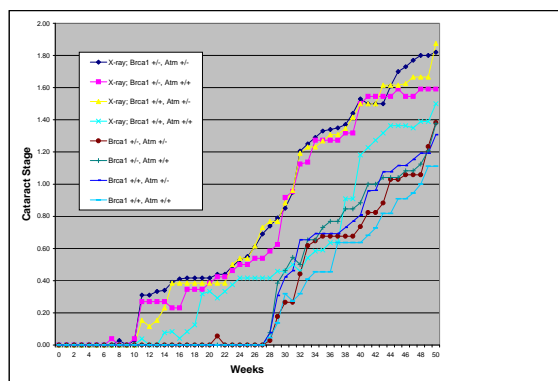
Influence of dual haploinsufficiency for *Atm* and *Brca1* on radiation cataract development after exposure to 500 mGy X-ray. *Invest. Ophthalmol. Vis. Sci.* 47, 2006.
